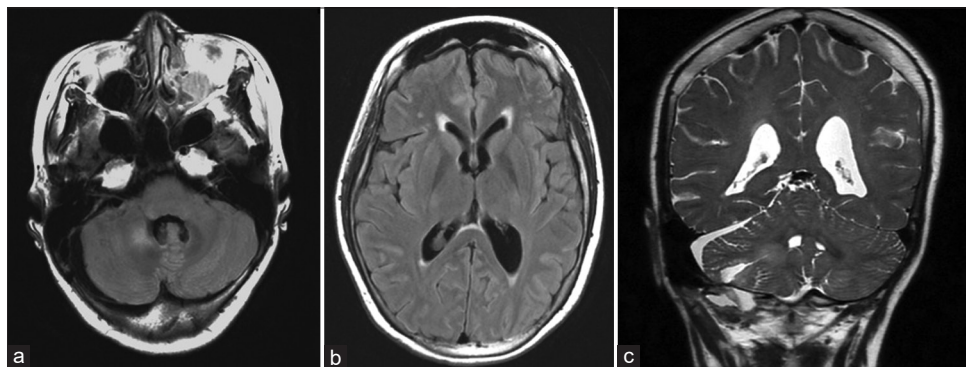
Postoperative FLAIR axial imaging showing that the tumor was successfully removed with no obvious residual tumor, and T2 coronal imaging showing that the hydrocephalus had improved (a-c).
